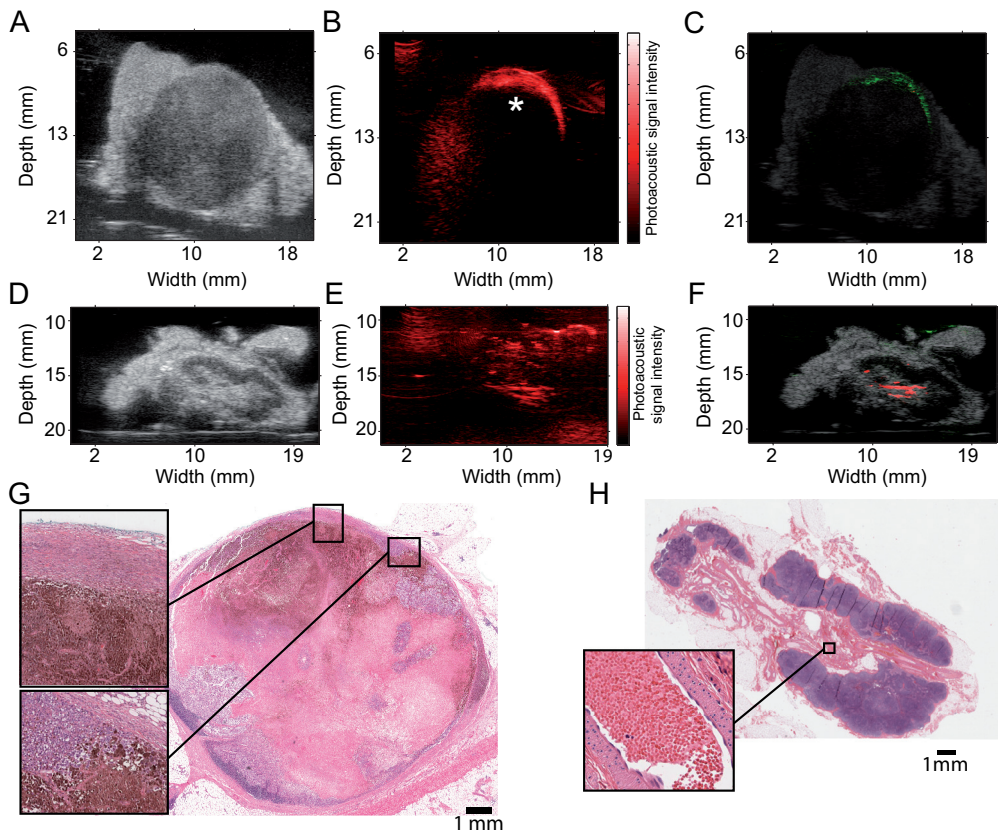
Images of two human nodes. The first row shows images of a metastatic node (node number 2 from Table 1); the second row shows images of a benign node (node number 3 from Table 1). Three columns represent, respectively, high-resolution ultrasound, photoacoustic signal, and the calculated resemblance. The third row shows the pathology slides of the metastatic node (G) and the normal node (H). Absence of photoacoustic signal deeper in the malignant node (as indicated by * in B) seems to be caused by the strong absorption by the melanin in the superficial area of the node. The green area in (c) corresponds to the superficial layer of the dark area in G. The red structure in F corresponds to the vessels in the hilum of the benign lymph node (H).
